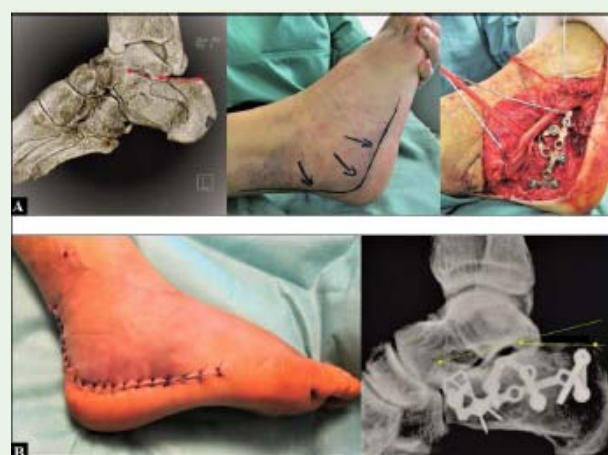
(54-year old male, calcaneal fracture, left): (A) Initial findings and open reduction and internal locking plate fixation, note the completely collapsed Böhler's angle in 3D computed tomography (red points and lines) that means that there is a traumatic fracture-related flat foot. (B) The Böhler's angle could be good restored (green points and lines).
